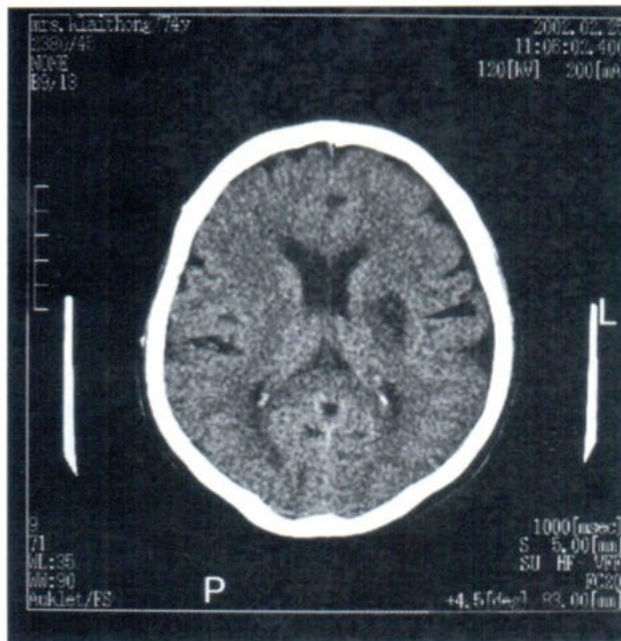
Another patient with positive early CT signs showed subsequent large infarction with hemorrhagic transformation.
